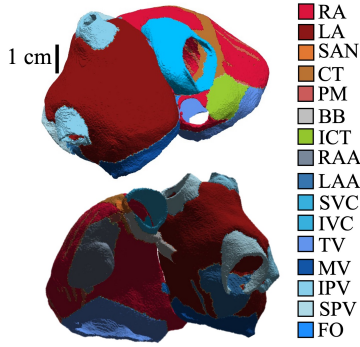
Detailed, 3D volumetric bi-atrial geometry derived from MRI represented with colors according to different tissue types. RA: right atria; LA: left atria; SAN: sinoatrial node; CT: crista terminalis; PM: pectinate muscle; BB: Bachmann bundle; ICT: cavo-tricuspid isthmus; RAA: right atrial appendage; LAA: left atrial appendage; SVC: superior vena cava; IVC: inferior vena cava; TV: tricuspid valve; MV: mitral valve; IPV: inferior pulmonary veins; SPV: superior pulmonary veins; FO: fossa ovalis.
